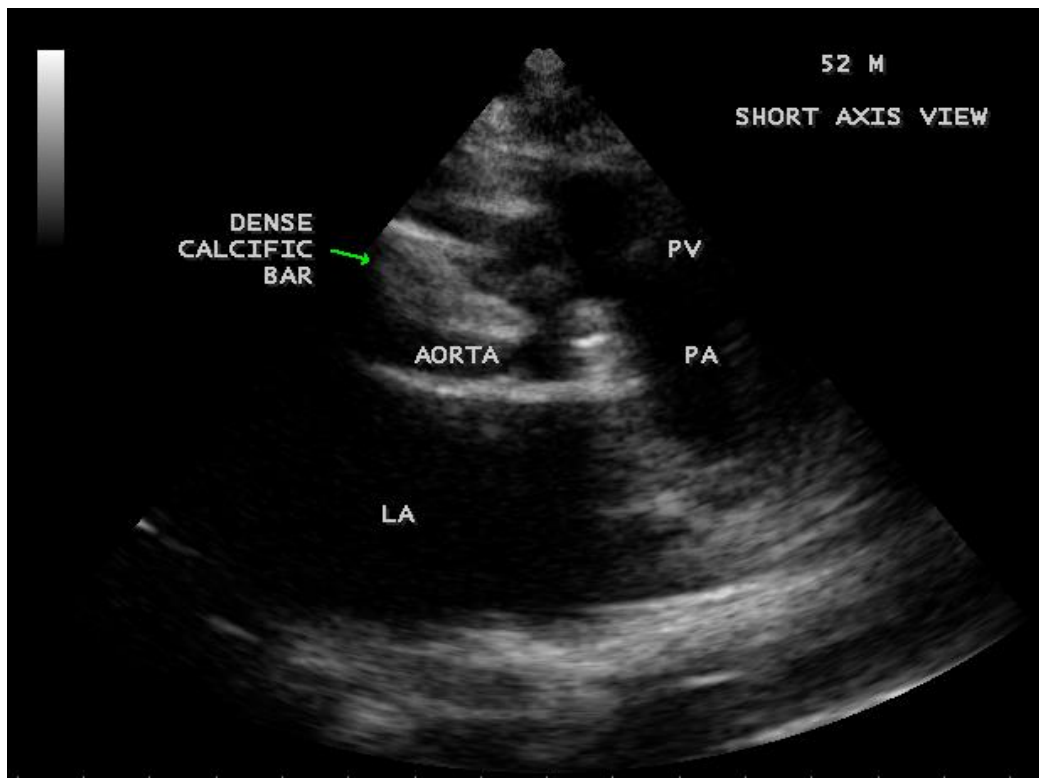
Parasternal long axis view showing the calcific bar of anterior mitral leaflet and aortic valve in a 52-year old male.
